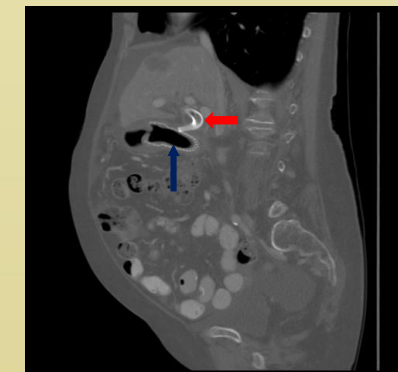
CT visualization after successful deployment of choledochoduodenostomy (red arrow) and esophageal (blue arrow) stents.
